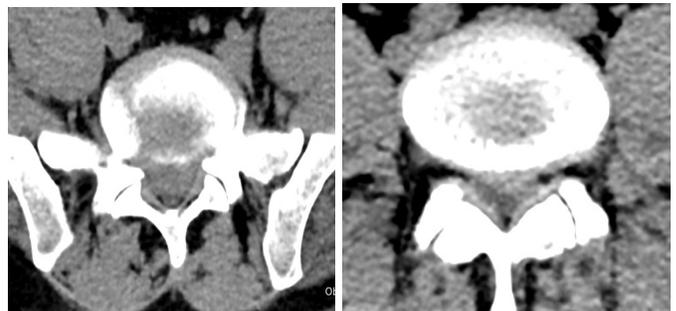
CT, sagittal and axial views. The disc herniations at L4–L5, L5–S1, spondylolisthesis L5.
